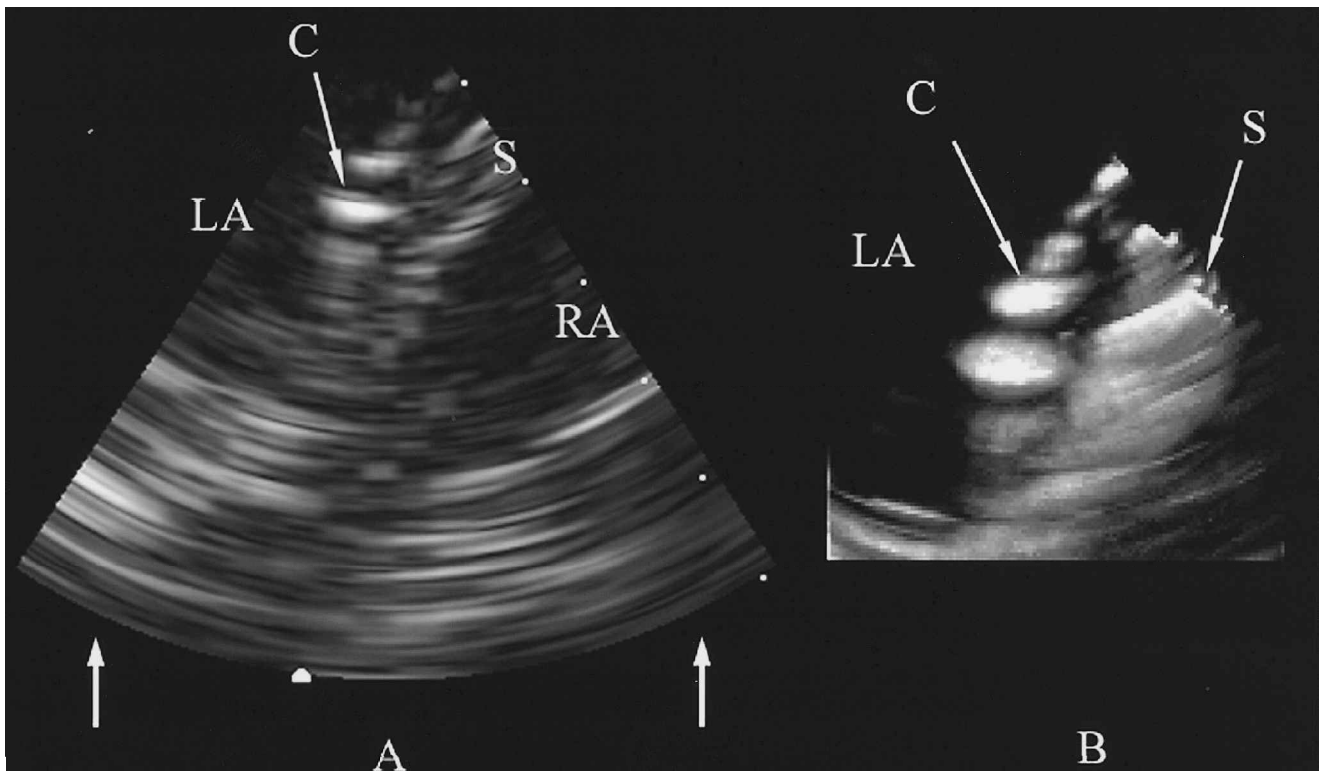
Three-dimensional intracardiac echocardiographic (ICE) scan with imaging catheter in the left atrium (LA) including (A) a sector image of the LA, septum S, right atrium (RA), mapping catheter C, (B) simultaneous real-time three-dimensional image obtained by rendering the volumetric data in the pyramidal scan between the two bold arrows in (A).
